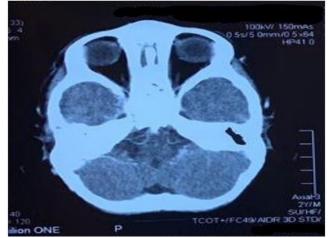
Repeated CT Brain after completion of chemotherapy show significant reduction in extraosseous soft tissue which indicates good response of the tumour with chemotherapy.
